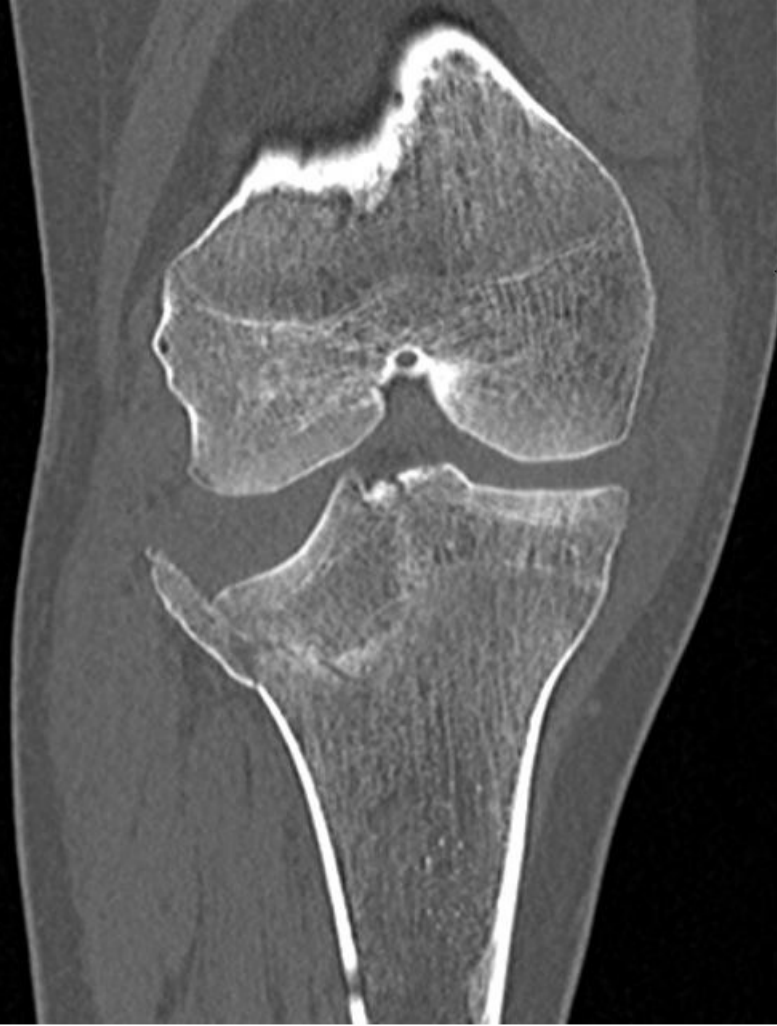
pre and post operative (7 month) CT scans in a 64-year-old patient with a Schatzker VI fracture and posterior depression
